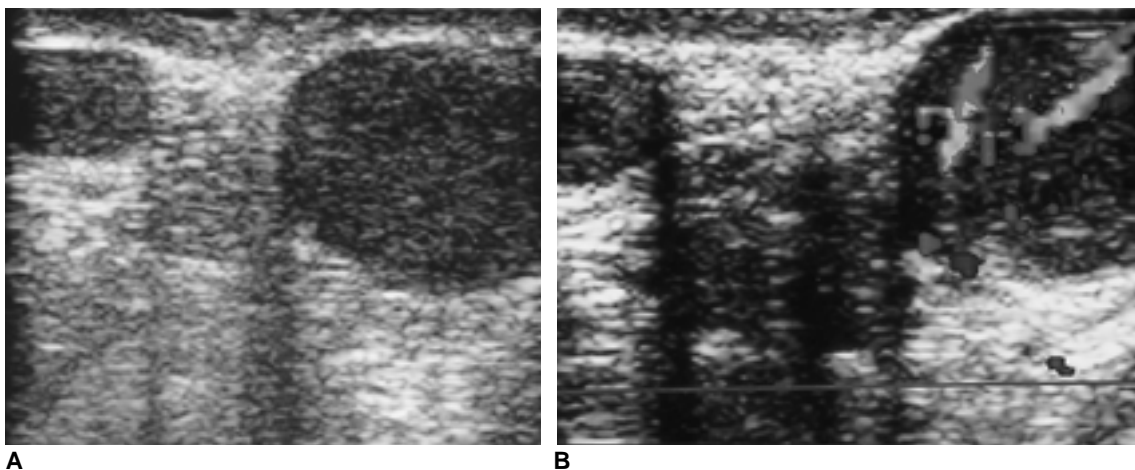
A 8-year-old boy with a history of ALL. A. Transverse gray-scale US on both testes shows marked enlarged left testis but has normal homogeneous isoechogenicity. B. Transverse color Doppler image on both testes shows marked diffuse hypervascularity of the involved left testis. Note an absence of vascularity on the normal right testis in the same color gain settings. The color Doppler application in this case showing normal echogenicity was helpful in detecting leukemic involvement.
